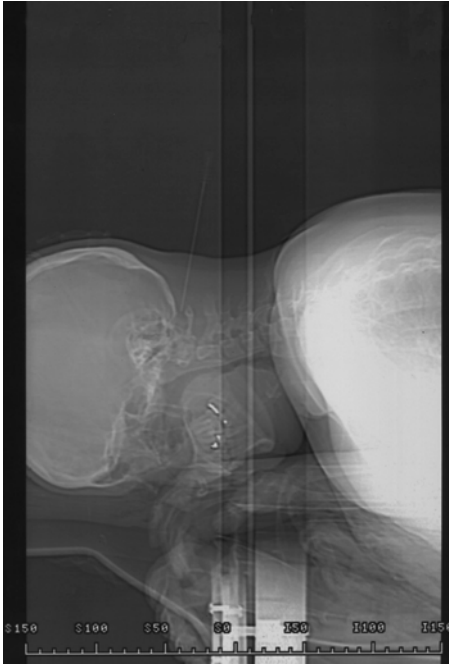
Lateral radiograph of extralemniscal myelotomy at occiput-C1 level
